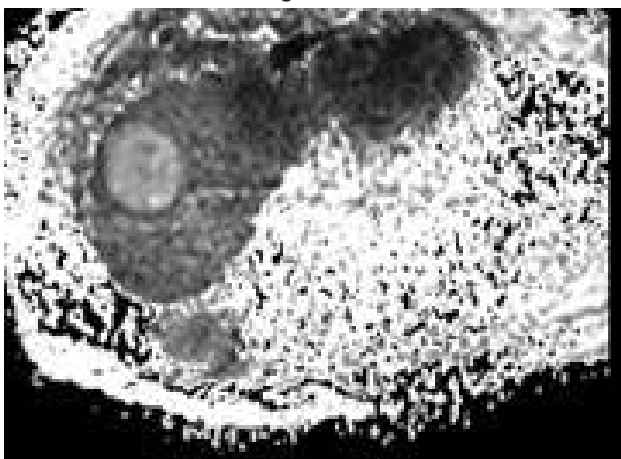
MR images in 38 year-old woman man with hemangioma of sgment 5. The hemangioma demonstrates free diffusion: It is hyperintense on T2 WI (a) and hypointense on DW MRI at b-1000 s/mm² (b), with high ADC 2.4 s/mm² (c).
